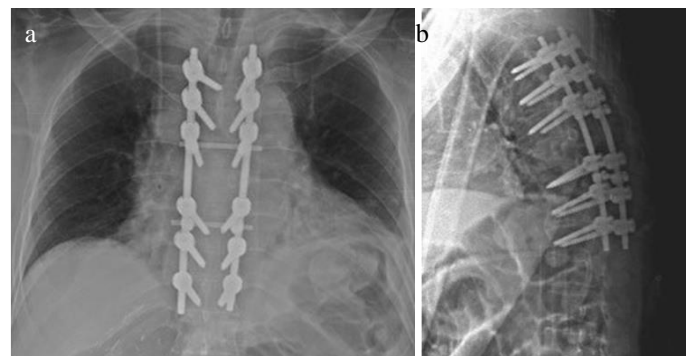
Postoperative anteroposterior (a) and lateral (b) X-rays after posterior wide resection and spinal instrumentation for T7 metastasis
